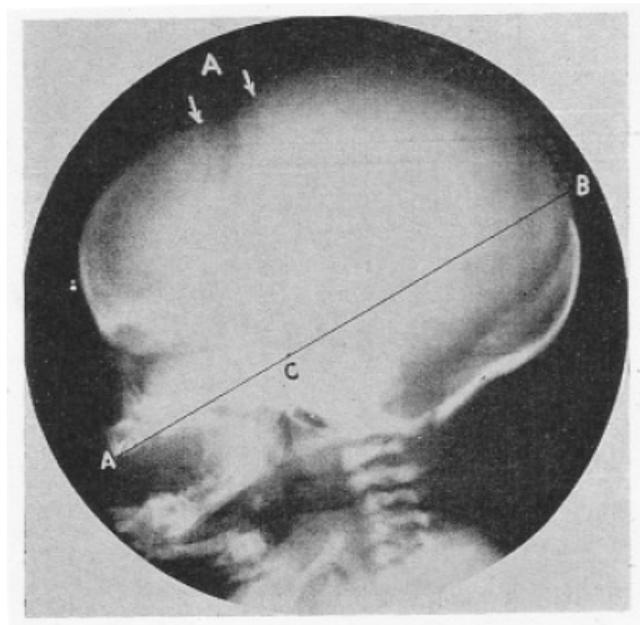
Lateral radiograph of a newborn after elective caesarean section, showing an unmoulded head. There is no overlap or elevation of the parietal bones at the anterior fontanelle A and the posterior fontanelle B. (Reproduced from Moloy¹²⁹)
